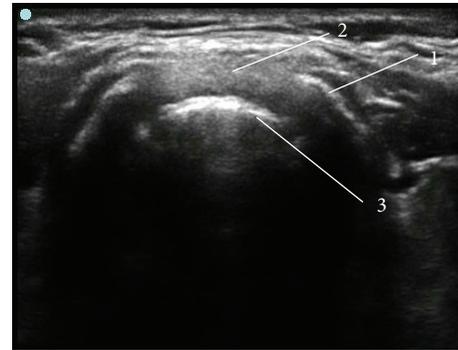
Ultrasound visualization of a stent inserted into the trachea. (1) Tracheal wall, (2) intratracheal stenotic tissue, and (3) anterior part of the tracheal stent.
